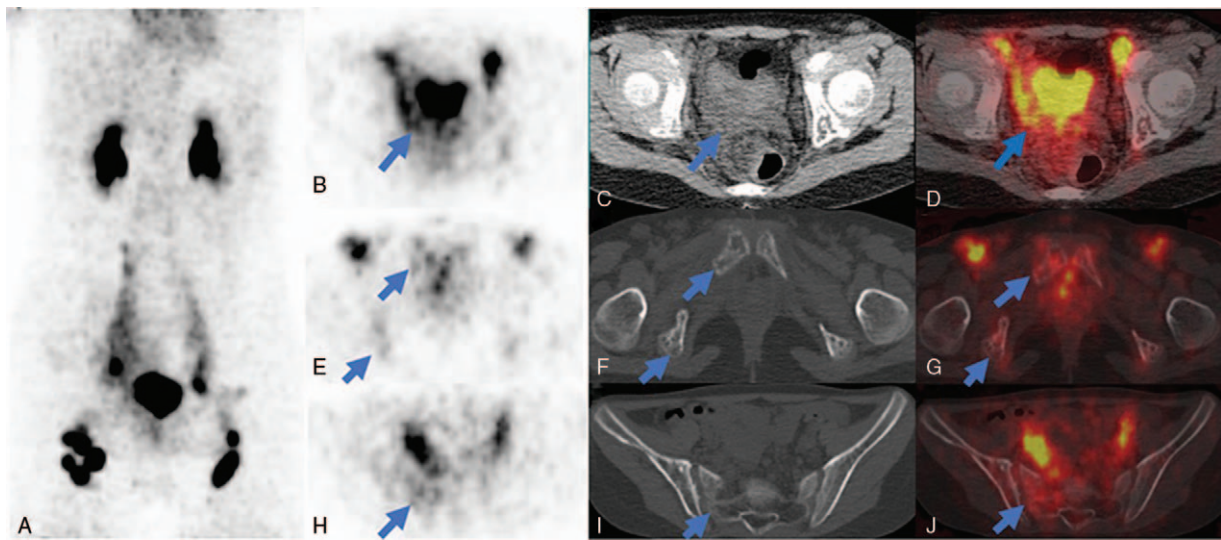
The ^{68}Ga -NEB PET/CT images (A, MIP; B–D, transaxial PET, CT, and fusion; E–G, transaxial PET, CT, and fusion; H–J, transaxial PET, CT, and fusion). ^{68}Ga -NEB PET/CT results show several round and strip-shaped low-density shadows with mildly increased radioactive uptake in both bladder (B–D, blue arrows) wall and pelvis, including sacral, pubic, and ischial bones (E–J, blue arrows). CT = computed tomography, MIP = maximum intensity projection, NEB = NOTA-Evans Blue, PET = positron emission tomography.
